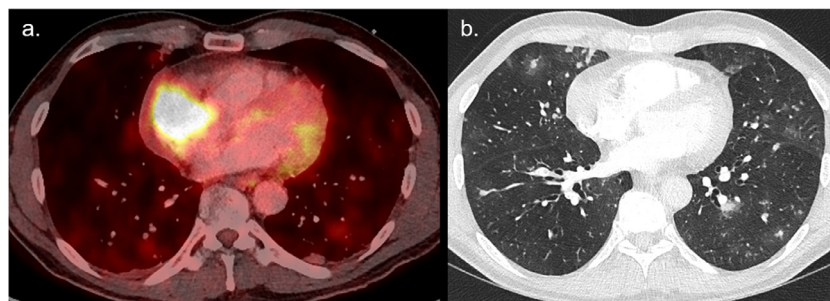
Angiosarcoma with hemorrhagic pulmonary metastases. (A, B) 62 y/o male with cardiac angiosarcoma (A) Fused ^{18}F -FDG PET/CT shows primary tumor in the right atrium with increased ^{18}F -FDG uptake. (B) Chest CT shows bipulmonary hemorrhagic metastases (ground glass attenuation surrounding solid nodules) in random distribution.
